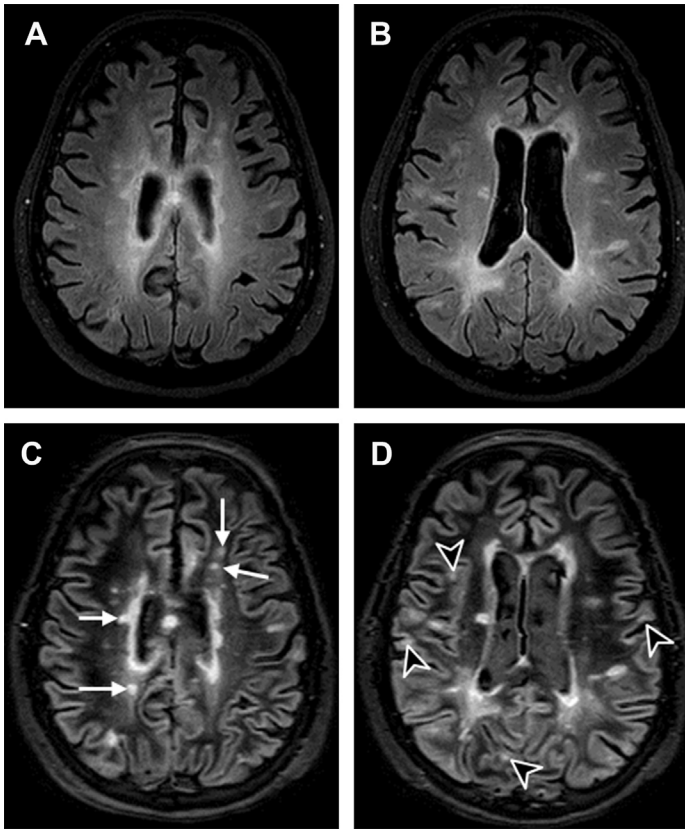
Demyelinating lesions are shown on 3D FLAIR (*top row*) and 3D double inversion recovery (DIR, *bottom row*) in multiple sclerosis. (A–C) and (B–D) image pairs show the same slices. Increased lesion contrast is seen on the DIR images, which allows for an improved differentiation of deep white matter lesions (*white arrows in C*) as well as juxtacortical and cortical lesions (*arrowheads in D*).
